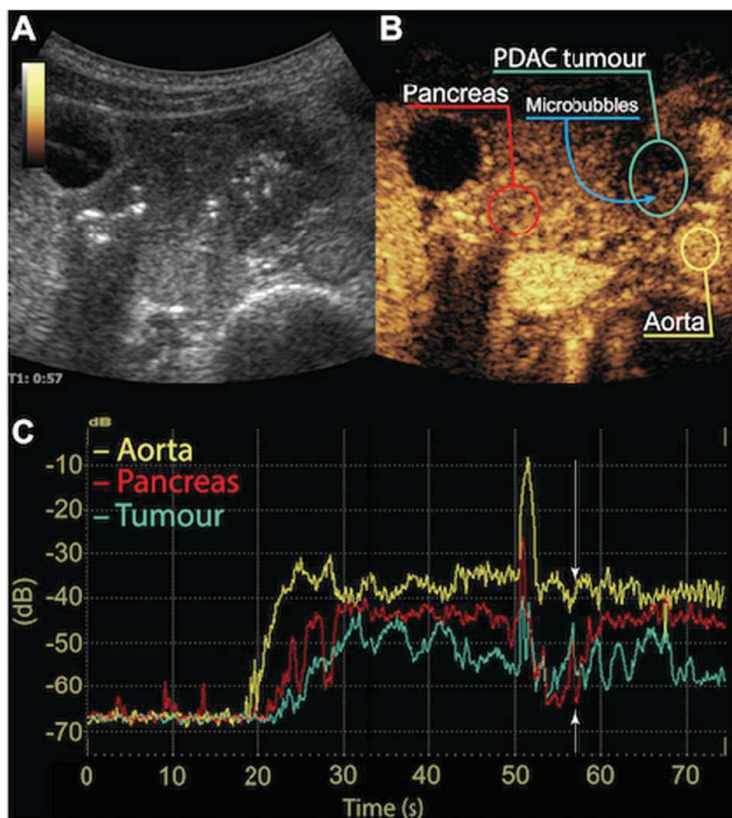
Contrast-enhanced ultrasound of the PDAC tumour in Patient 7. Panel A: B-mode image. Panel B: Contrast-Enhanced ultrasound using SonoVue® microbubbles. Pancreatic tissue, the PDAC tumour and aorta have been labeled. Microbubbles can be clearly distinguished in the PDAC tumour when comparing to the B-Mode image. Panel C: Perfusion curve depicting non-linear echo amplitude as a function of time for the three regions of interest: Aorta (yellow), pancreatic tissue (red) and PDAC tumour (cyan). The PDAC tumour exhibits a longer time-to-peak and lower perfusion than both the aorta and pancreas, yet is still adequately perfused for microbubbles to enter. Panels A and B are freeze frames of late phase perfusion, 57 s after microbubbles injection (*cf.*, white arrows in Panel C).
